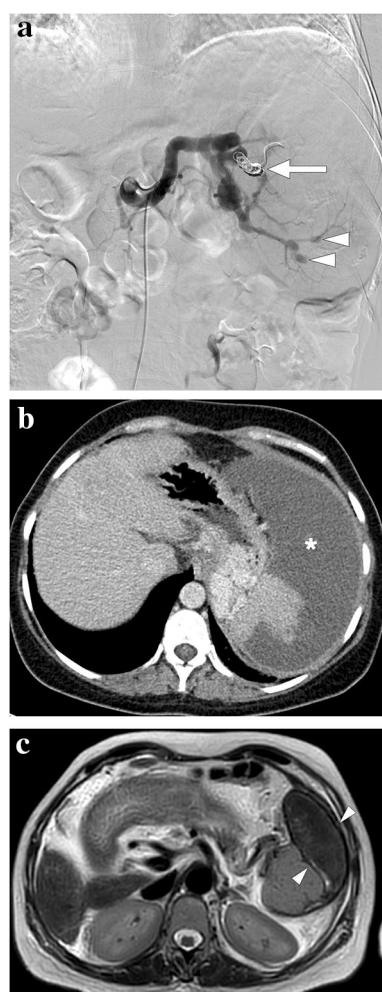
A 39-year-old female patient with known cryptogenic cirrhosis, severe portal hypertension, and hypersplenism underwent partial splenic artery embolization. a Catheter angiography image shows the occluded upper pole branch of the splenic artery (arrow) with micro-particle and coil embolization. Noted were multiple saccular aneurysms in the distal arterial branches of the lower pole (arrowheads). b Follow-up contrast-enhanced abdominal CT 6 weeks after the embolization shows large iatrogenic splenic infarction (asterisk). c Follow-up abdominal MR image 2 years after the embolization demonstrates the chronic phase of splenic infarct with a smaller size of the spleen and low T2 signal intensity within the regressed infarcted segment (arrowheads)
